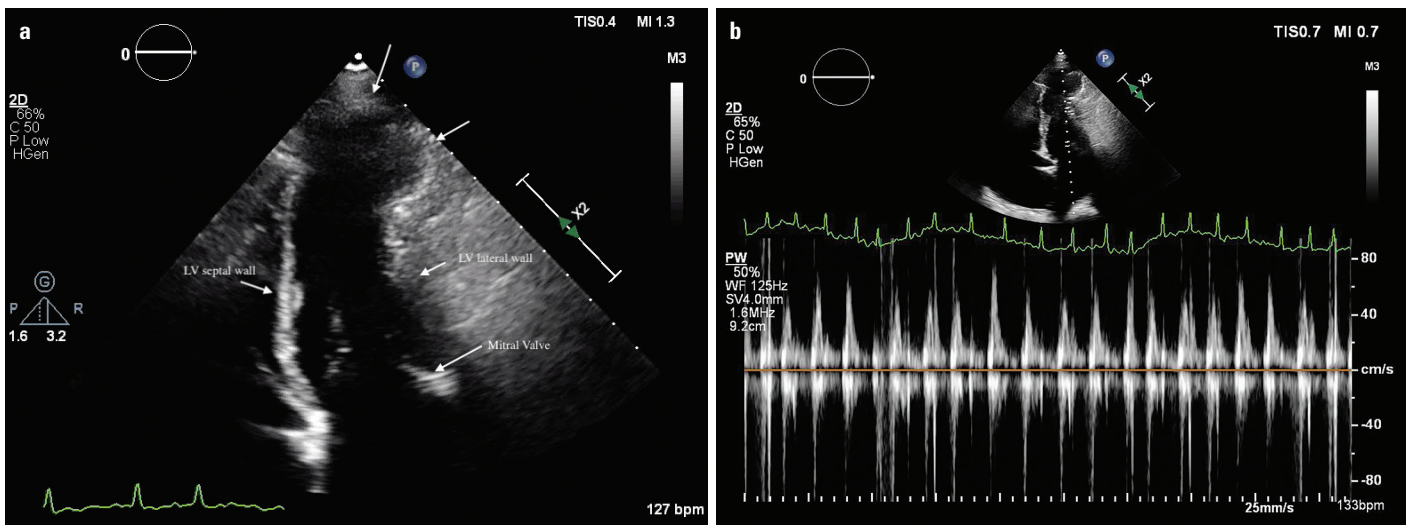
(a) Echocardiography image showing the LV apical outpouching (white arrows). (b) Pulse wave Doppler images of the mitral inflow, which showed respiratory variations
